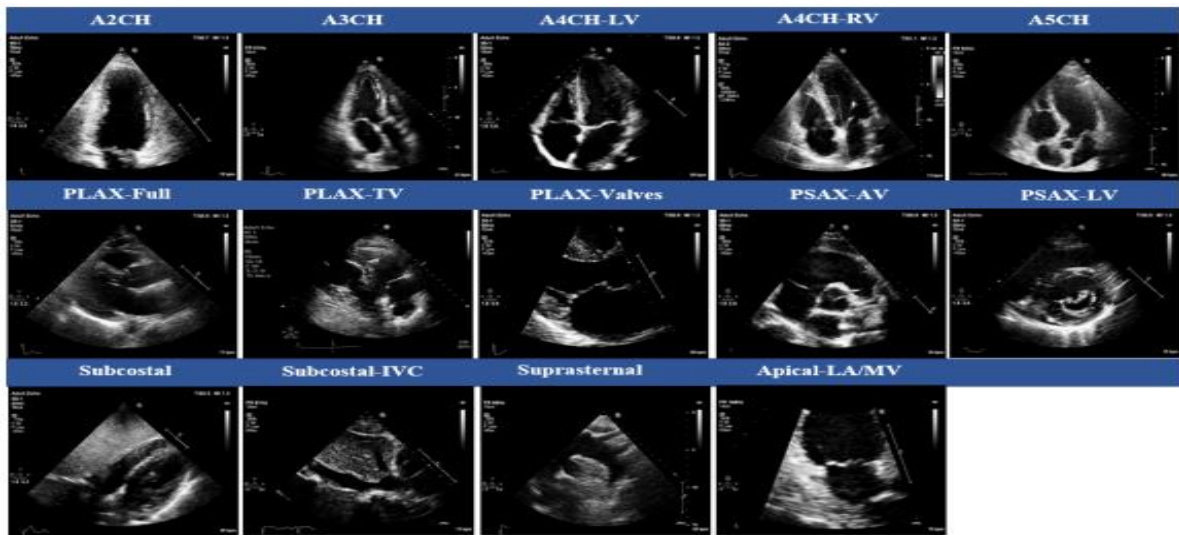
Samples of 14 cardiac views used in this study: apical two chamber (A2C), apical three-chamber (A3CH), apical four-chamber left ventricle focused (A4C-LV), apical four-chamber right ventricle focused (A4C-RV), apical five-chamber (A5C), parasternal long-axis (PLAX-Full), parasternal long-axis tricuspid valve focused (PLAX-TV), parasternal long-axis valves focused (PLAX-Valves), parasternal short-axis aortic valve focused (PSAX-AV), parasternal short-axis left ventricle focused (PSAX-LV), subcostal (Subcostal), subcostal view of the inferior vena cava (Subcostal-IVC), suprasternal (Suprasternal), and apical left atrium mitral valve focused (LA-MV).
